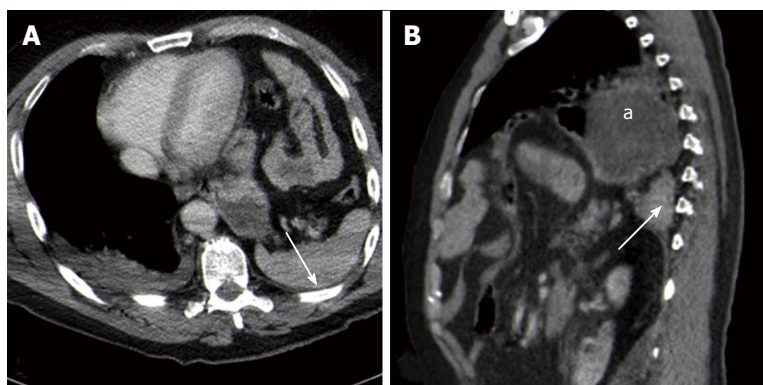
Computed tomography findings in blunt diaphragmatic lesions - dependent viscera sign. These 3 mm thick multiplanar axial (A) and coronal (B) reconstructions show the spleen (arrows) and the stomach (a) lying on the posterior chest wall, without lung parenchyma interposition. This alteration represents the so-called "dependent viscera sign".
